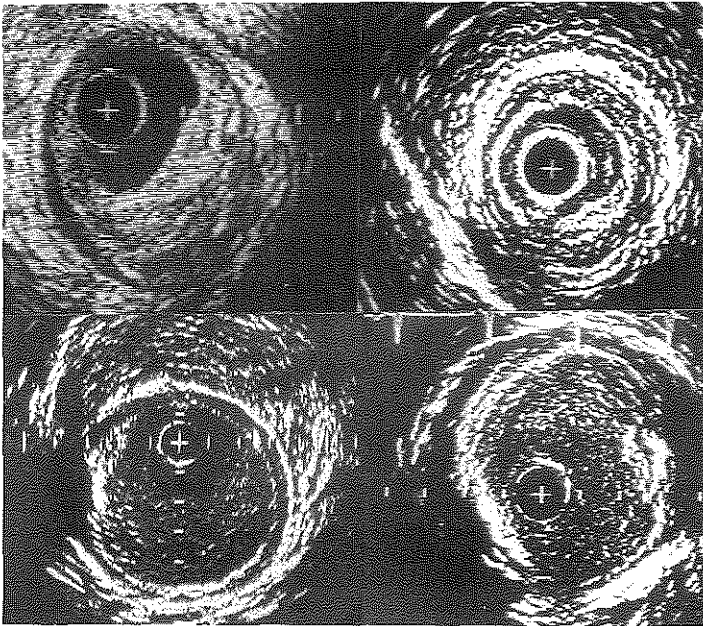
Intravascular ultrasound cross-sections obtained *in vivo* showing the similarities between the femoral (left) and coronary (right) arteries. Top panel: cross-sections showing similarities of a soft lesion. Lower panel: cross-sections showing similarities in the presence of hard lesion casting ultrasonic shadowing. Note the echogenicity of blood inside the lumen in the lower panel. Calibration=1 mm.
